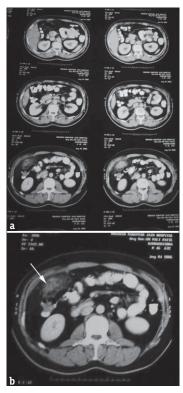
(a) CT scan image showing an inflammatory mass localised to the right colon with fat stranding (b) Detailed image of CT
